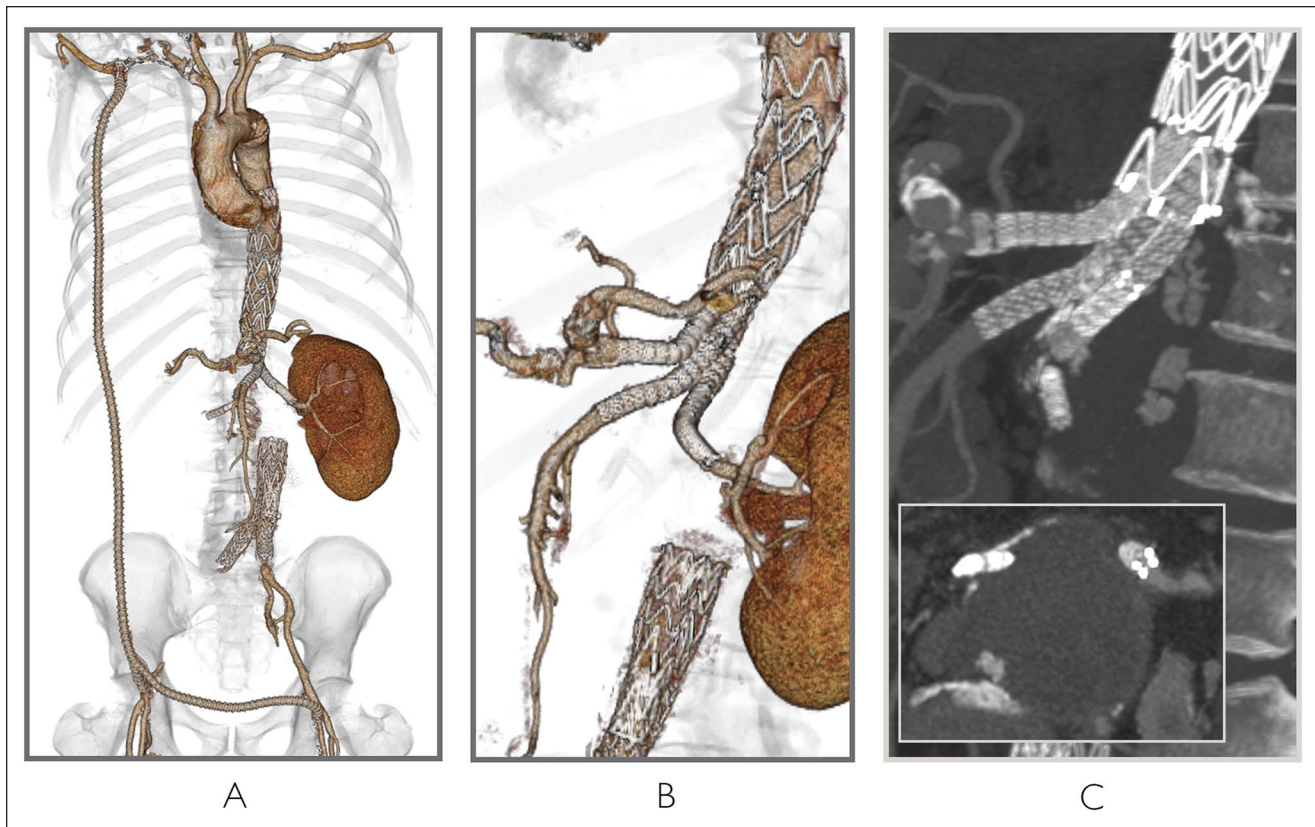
Postoperative computed tomography angiography with 3D volume rendering (A and B) and multiplanar reconstruction (C) showing the complete exclusion of the aneurysm, patency of all target vessels arising from the visceral aortic stump and patency of the extra-anatomical revascularization of lower limb. Due to proximal exclusion with the stent-graft and distal aortic occlusion, a small quantity of contrast media remained entrapped in the aneurysm sac (C).
